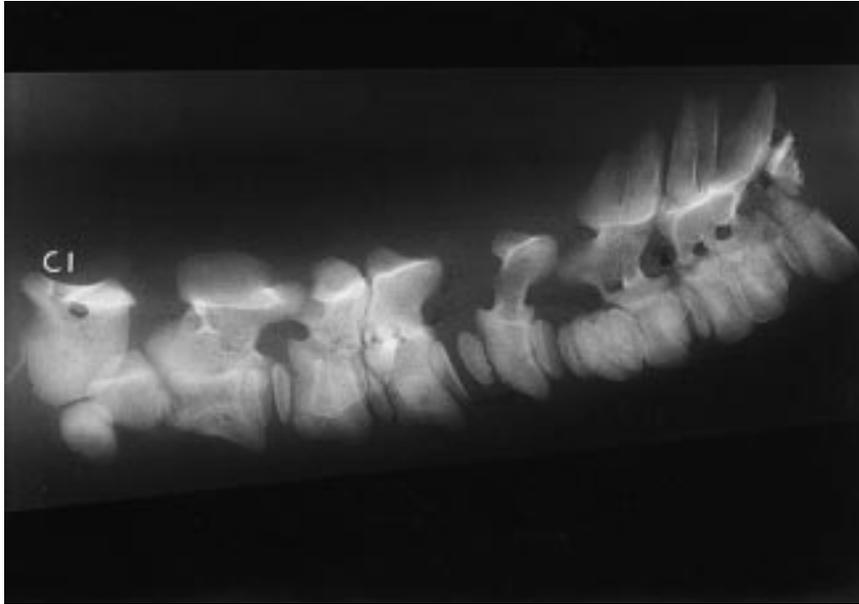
Cervical spine; calf. Lateral radiographs of sagittal slices. Block vertebrae are identified at C3-4, C6-7, and T1-2. Vertebral arches of C5 and C6 were only partially formed. C5 vertebra is angled dorsally relative to the C4 vertebra.
